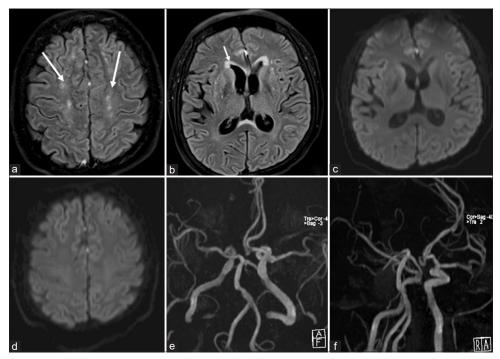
Case 1. MRI done 48 hours after the onset of symptoms. Axial FLAIR images showed patchy hyperintense foci in bilateral frontal white matter (White arrows in a) and the periventricular white matter with presence of ependymitis granularis (white arrow in b). No evidence of new infarcts or hemorrhage seen on Diffusion-weighted images (c, d). Time-of-flight MR angiogram (e, f) showed no evidence of residual aneurysmal filling and no vascular occlusion
